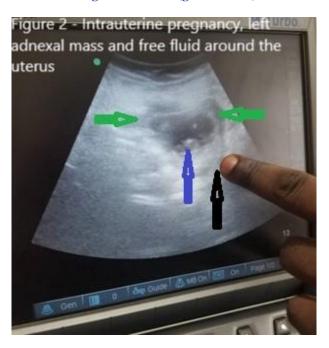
Transabdominal ultrasound showing a left adnexal mass (black arrow), the intrauterine pregnancy (blue arrow) and free fluid surrounding the uterus (yellow arrows).
